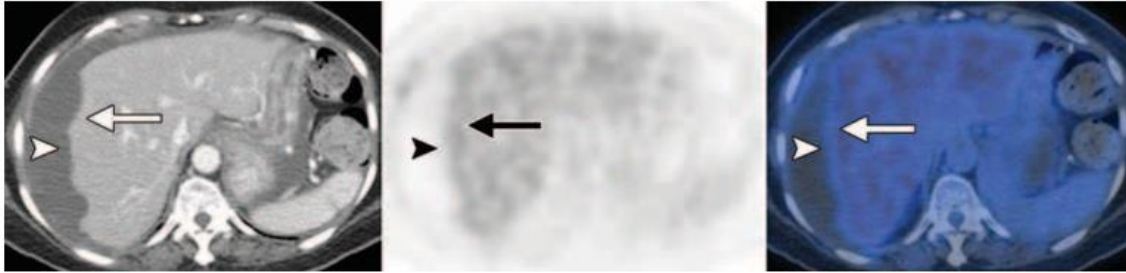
False-negative PET results in a 76-year-old woman with miliary peritoneal carcinomatosis, elevated CA-125 levels, and a history of total abdominal hysterectomy (TAH), bilateral salpingo-oophorectomy (BSO), omentectomy, lymph node dissection, and chemotherapy for stage IIIC ovarian mucinous cystadenocarcinoma. Axial contrast-enhanced CT (left), FDG PET (middle), and fused PET/CT (right) images show perihepatic ascites compressing the liver parenchyma (arrowhead), which is not metabolically active. Mild FDG uptake (mean maximum standardized uptake value [SUV_{max}], 2.3) similar to background liver uptake is seen along the peritoneal surface of the hepatic convexity (arrow), although CT clearly shows scalloping along the liver parenchyma, a finding indicative of peritoneal carcinomatosis. A limitation of FDG PET/CT is its inability to depict cystic or necrotic and mucinous lesions. It may also have false-negative results for small-volume disease (<7 mm) and miliary, diffuse peritoneal involvement.
